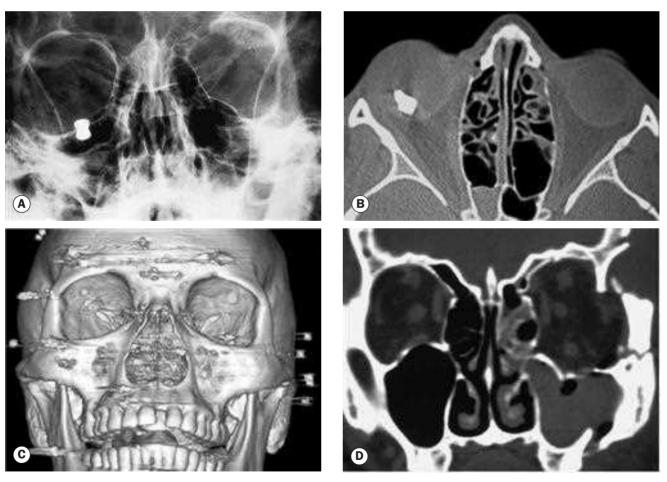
Imaging of ocular trauma. (A) Plain radiograph showing a lead air gun pellet; (B) axial CT showing a localized intraocular foreign body in the left eye; (C) 3-dimensional CT reconstruction of a facial shotgun injury; (D) coronal CT showing left lateral orbital wall fracture
